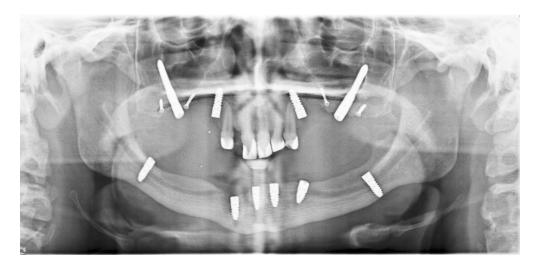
The panoramic x-ray image of the same ectodermal dysplasia patient 18 months after implant insertion surgery. Note: The conventional implants in the lower jaw of this patient were inserted using the technique of bypass of the inferior alveolar nerve. In this case, the position of the nerve was superficial, situated rather buccally in the mandibular bone and insertion of the implant was possible without damaging the nerve.
